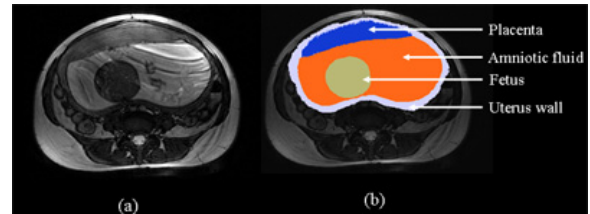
Example of transverse images before and after identification of tissues. (a) Original MR image, (b) tissue-identified image at the same level.
